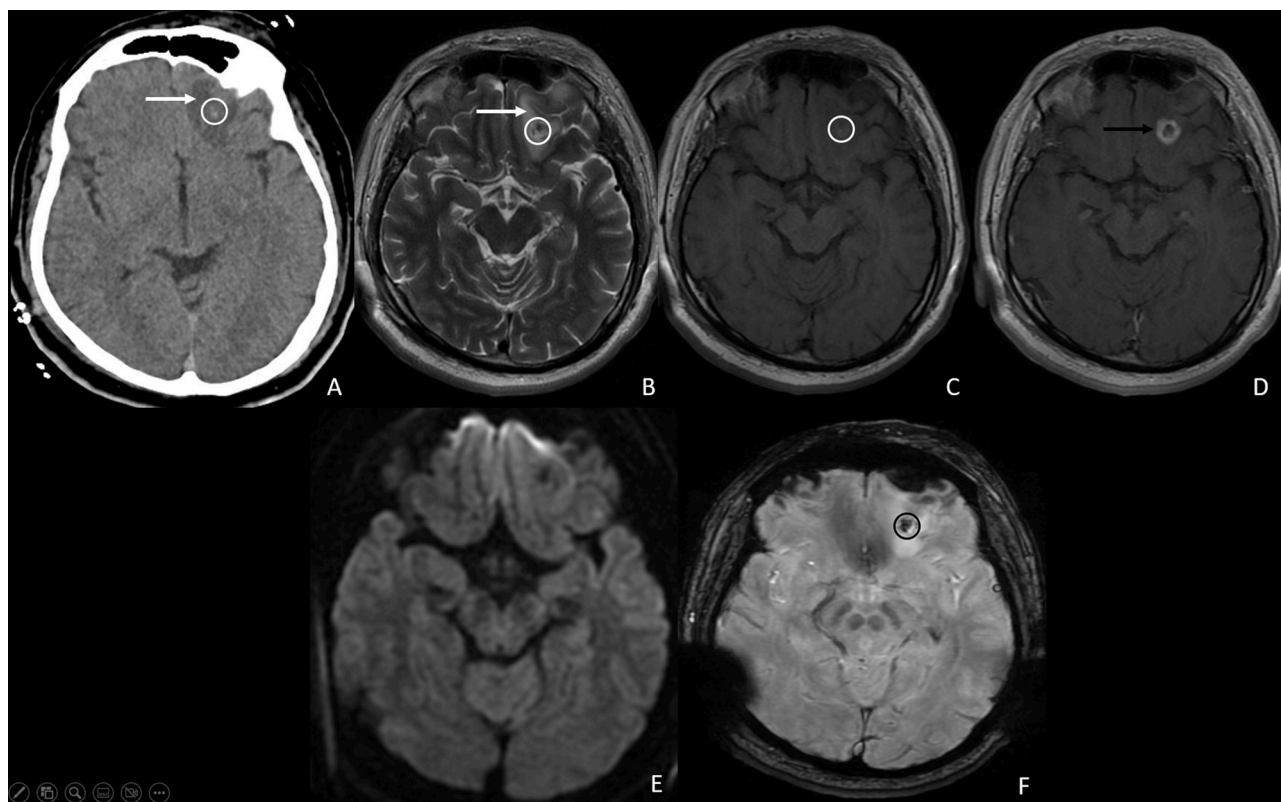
In the postoperative uncontrasted cranial CT axial sections of the patient (A), the left frontal millimetric contusion area (white circle) and perilesional edema around it (white arrow); contrast-enhanced cranial MR images likewise in T2 sequence axial image (B) frontal contusion (white circle) and perilesional edema (white arrow); circular contrast enhancement (black arrow) and frontal contusion area (white circle) on T1 non-contrast axial (C) and T1 contrast axial images (D); this lesion shows no diffusion restriction on diffusion-weighted axial sections (E) and microhemorrhages (black circle) on SWAIN sequence imaging (F).
